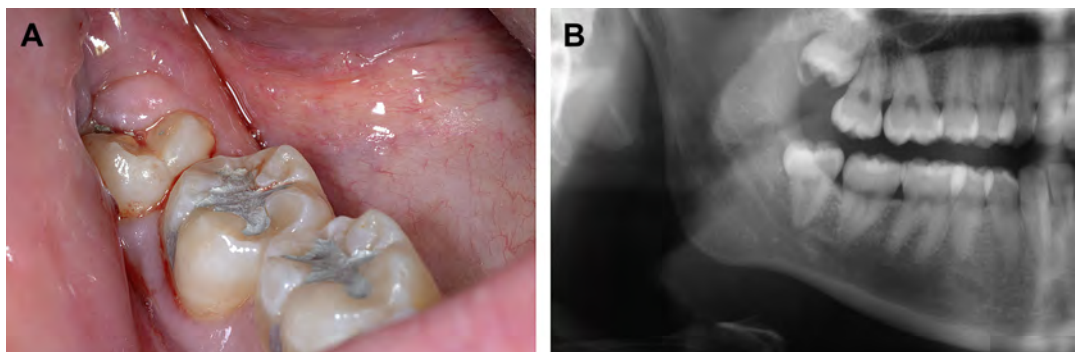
(A) Soft tissue impacted mandibular third molar. (B) Radiograph of soft tissue impacted mandibular third molar.
